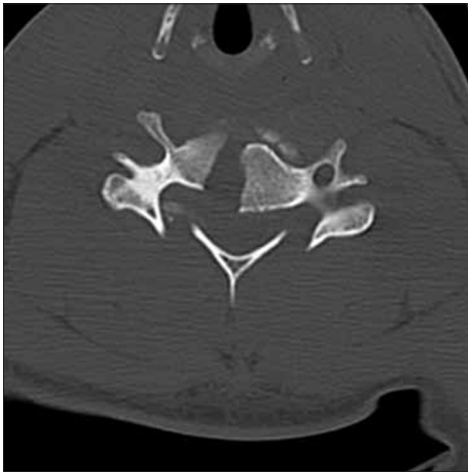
Preoperative axial computed tomography C5 burst fracture
